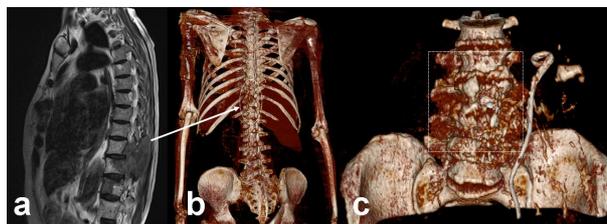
A case with renal cell carcinoma: (a) MRI, sagittal T1A view of a tumor lesion affecting the multiple compartments through the antero-posterior segments of the lower dorsal axis. (b) as a false negative case; 3D reconstructing image of the same lesion (arrow) is faint and cannot be neatly distinguished (circled area) (c) Heterogeneous irregular 3D views of the affected lower dorsal segments in another osteomyelitis case, leading to a false positive finding by mimicking the malignancy (squared area).
